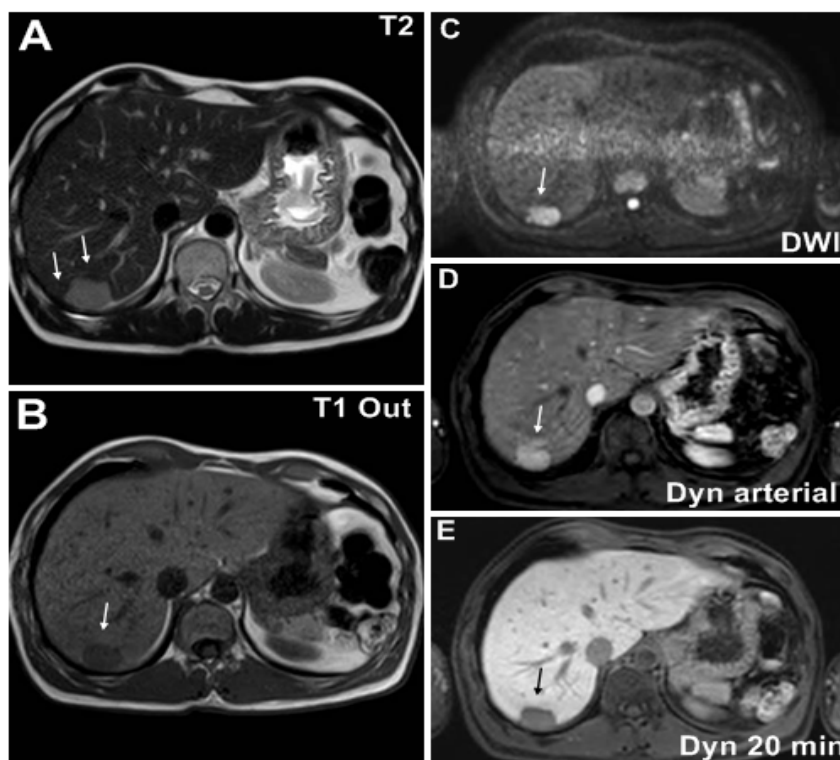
Hepatic magnetic resonance imaging (MRI) with morphological sequences in T2 (A), T1 out-of-phase (B), diffusion-weighted imaging (C) and arterial phase sequence post-gadolinium (D). Hepatobiliary phase 20 minutes after administration of hepatospecific contrast (E). Isolated well-defined nodular lesion in segment VII, homogeneous, hyperintense on T2 (A), hypointense on T1 (B), with diffusion restriction (C) and presenting hypervascular behavior in the arterial phase and hypointense in the hepatospecific phase (D and E).
